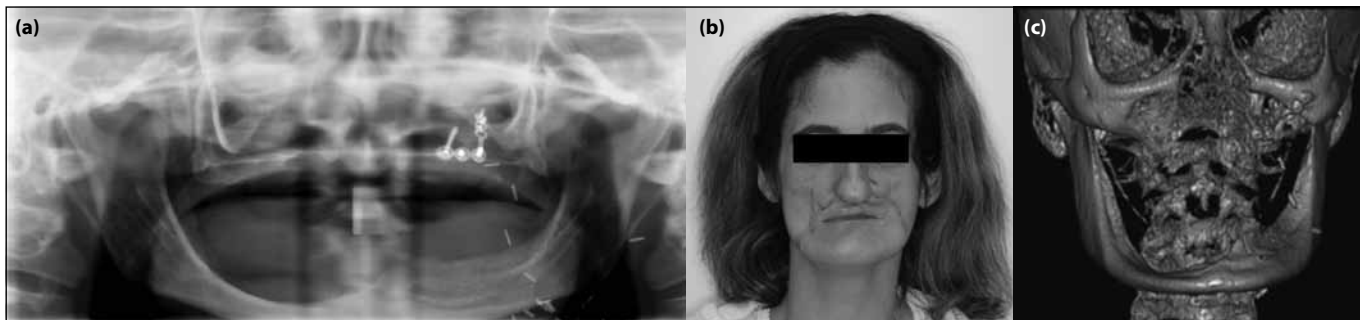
(a) Preoperative orthopantomography; (b) extraoral preoperative photograph; and (c) 3-dimentional reconstruction—initial clinical situation of the patient
